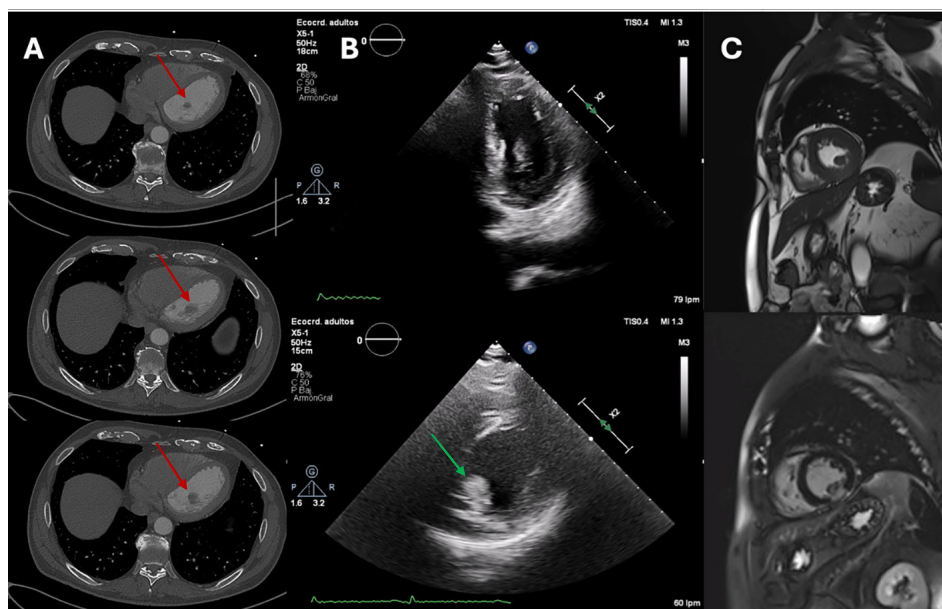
Column A (CT angiography slices). Column B (apical 2-chamber and short-axis echocardiogram images at mid-level). Column C. (short-axis T1 and late enhancement sequences).
